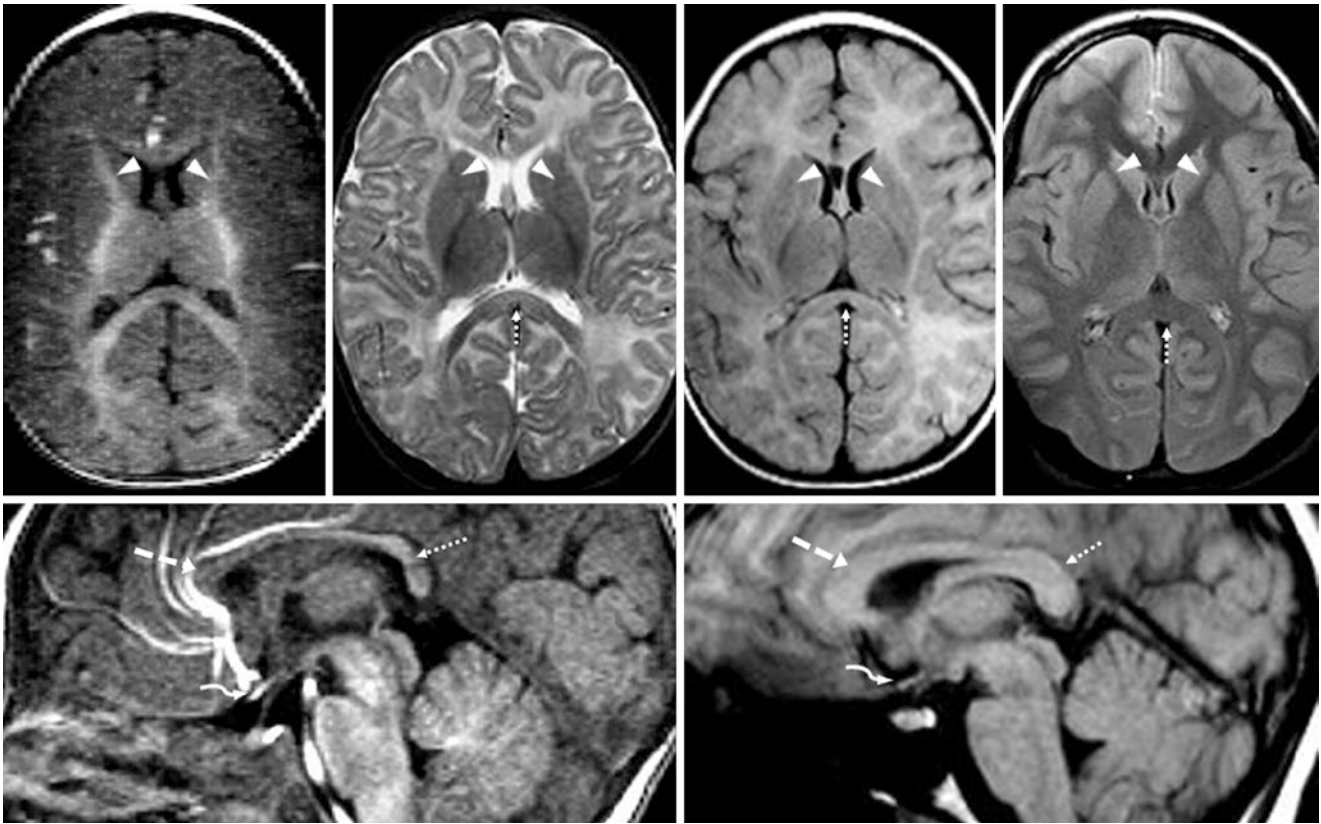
A 5.5-month-old with a possible visual deficit had a negative 1.5T MRI with GE T1WI (*top left*), SE T2WI (*top, left middle*), and FLAIR (*top, right middle*). The ALICs (*arrowheads*) are maturing on T1WI and are only slightly dark on T2WI. The PVWM is bright on FLAIR; a FLAIR image 13 years later in the same patient (*top, right*)
